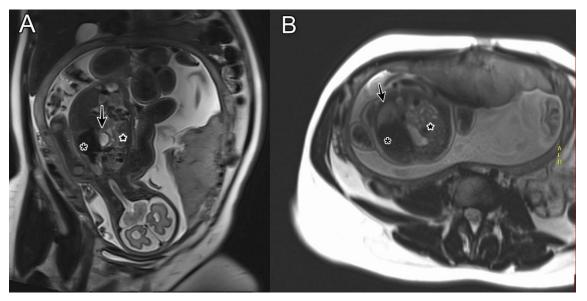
Foetal MRI. Sagittal (A) and axial (B) planes showing left side CDH with intestinal content in the thoracic cavity (star), the heart (arrow), and the right lung (asterisk).
